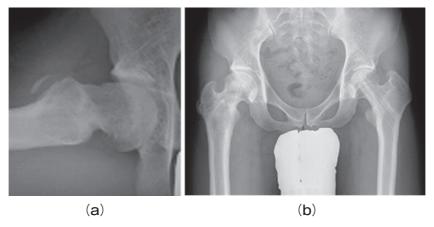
The latest lateral (a) and anteroposterior (b) radiographs 9 years after surgery. The patient was 22 years old and had no clinical symptoms. There was a morphologic abnormality on the radiograph (the α angle was 82° and the β angle was 70°).
